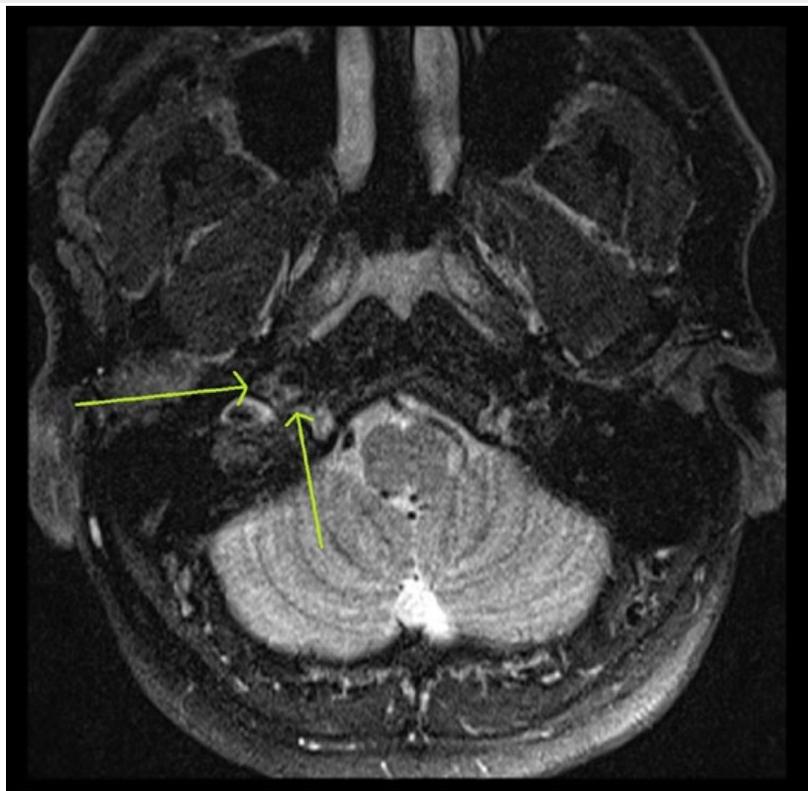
Axial MRI image of the intramural haematoma.
